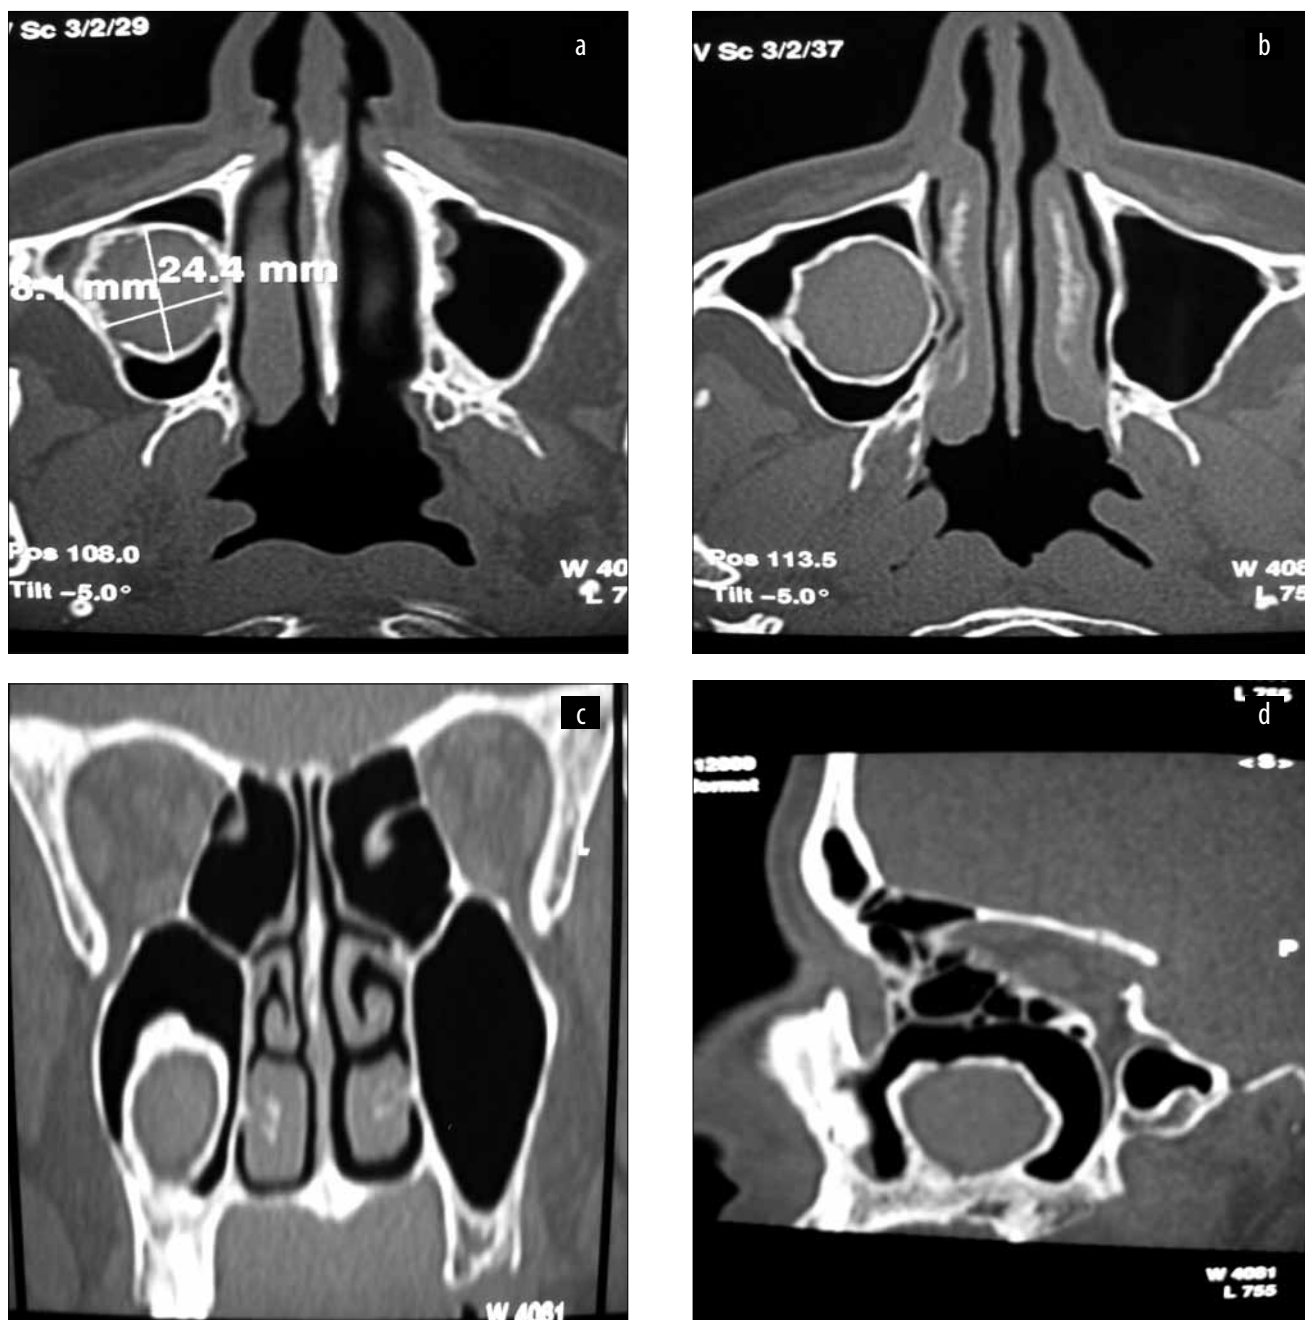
Cranio-facial CT scan – axial (a,b), coronal (c), sagittal (d) slices - oval osseous tumor of 18.1/24.4mm, with cystic resemblance - arising from the alveolar plate and occupying almost entirely the right maxillary sinus.
